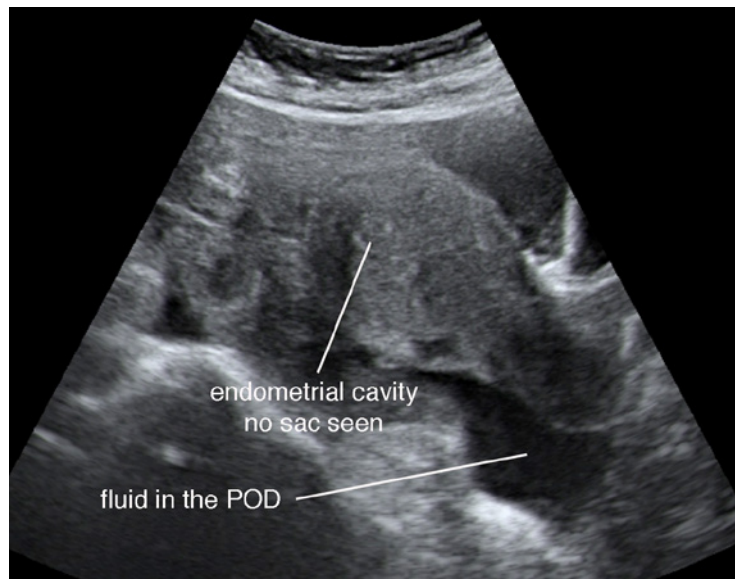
Ultrasound picture showing no gestational sac in the uterine cavity and fluid in the Pouch of Douglas.
